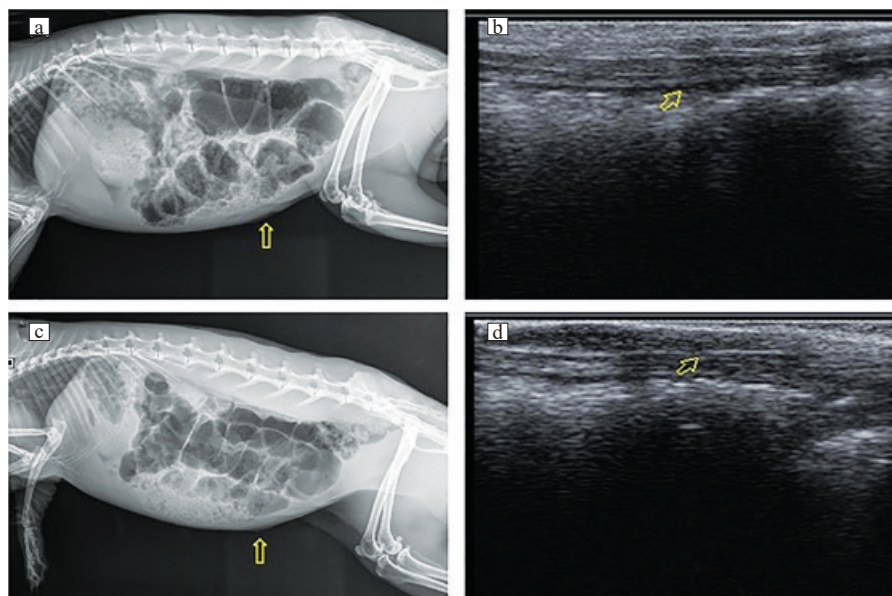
DR-X Ray and ultrasound imaging (yellow arrow) of tissue structure around 3D hernia mesh on day 24th post-surgery. (a) DR X Ray imaging, (b) ultrasound imaging on sham group, (c) DR X Ray imaging and (d) ultrasound imaging on 3D mesh hernia.
